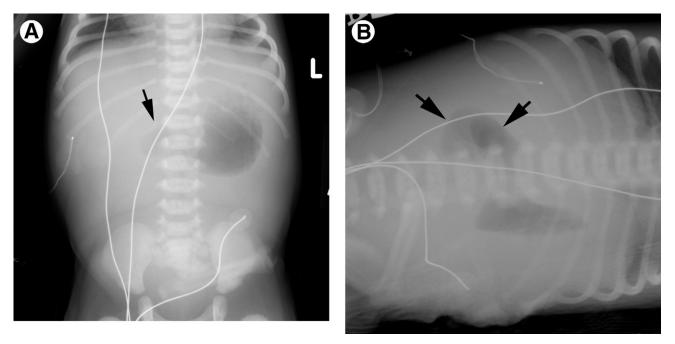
Newborn boy with malrotation and volvulus. The infant developed bilious vomiting shortly after birth. (A) Anteroposterior radiograph shows air only in the stomach and duodenum (arrow). (B) On a left-side down decubitus view, the duodenum (arrows) is better seen. The duodenum is mildly prominent but not dilated to the extent usually seen with duodenal atresia. An air-fluid level is seen dependently in the stomach. Ten centimeters of infarcted proximal small bowel were resected at surgery.
